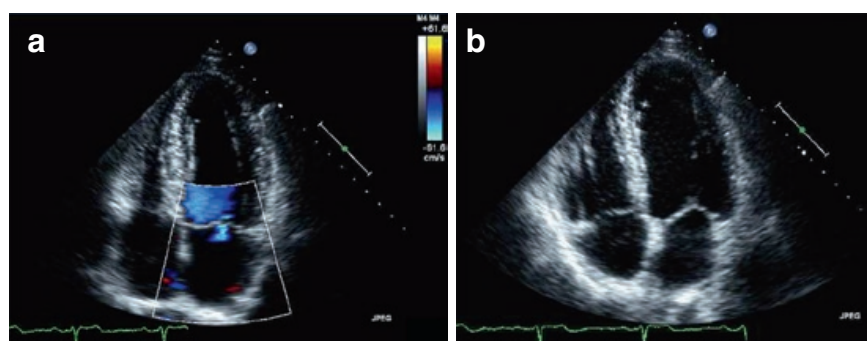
Echocardiogram at the first visit (Panel a: 4 chamber with color; panel b: 4 chamber without color).
